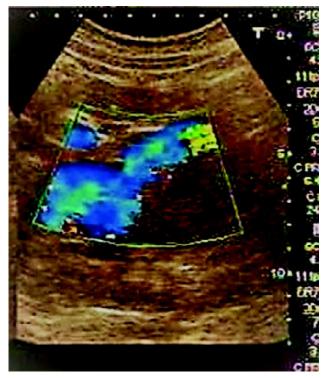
USG colour Doppler image showing venous flow in dilated cystic lesion adjacent to right hepatic vein showing venous flow on colour Doppler.
